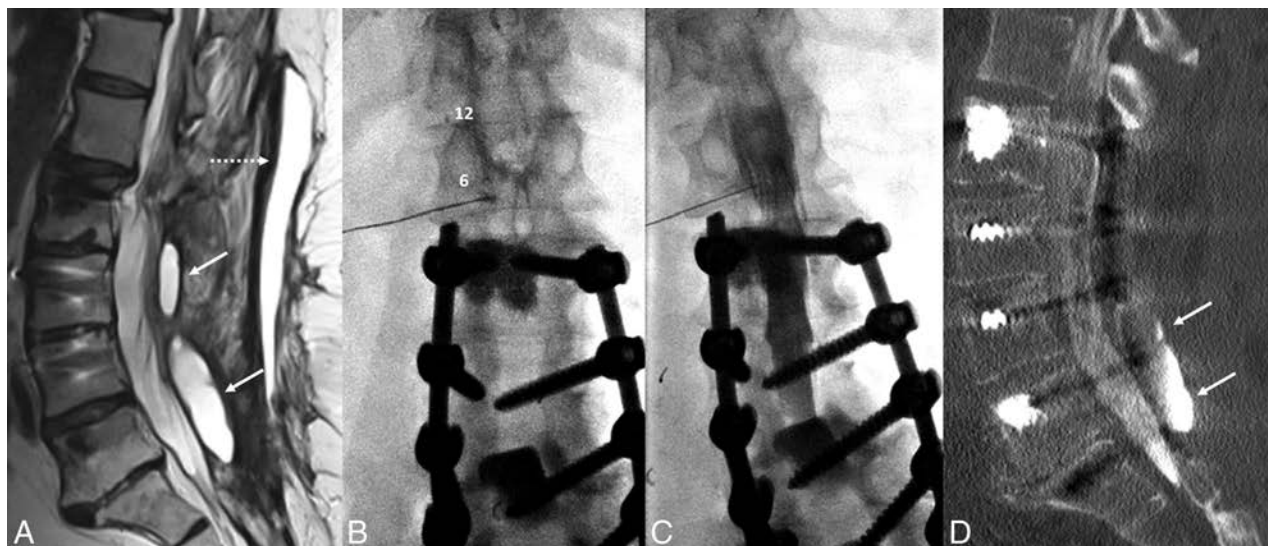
A 67-year-old woman with a history of multiple spinal fusions presented with newly worsening low back and radicular leg pain (case 1). Sagittal T2-weighted MR imaging (A) shows 2 paraspinous fluid collections (white arrows) within the deep paraspinal musculature and a midline subcutaneous fluid collection (dashed arrow) with rim enhancement on postcontrast series (not shown). B, Anteroposterior fluoroscopy image of myelography with TFLP. The needle tip is beyond the medial edge of the pedicle at the 5 o'clock position (relative to the pedicle). Note the position of the needle inferior to the expected location of the exiting nerve root and dorsal root ganglion. C, Oblique fluoroscopy image shows contrast extending into the intrathecal space after injection through the left L1–2 foramen. D, CT myelogram demonstrates the inferiorly located cystic collection filled with contrast, confirming a pseudomeningocele (arrows).
